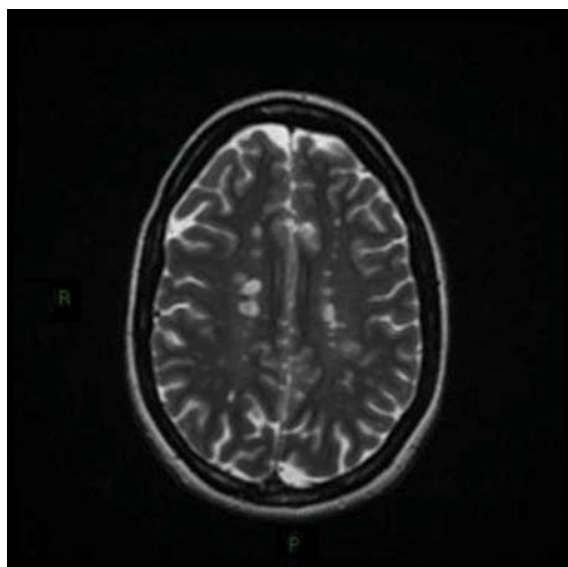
Axial T2-weighted image showing multiple ovoid periventricular white matter lesions, from subject 3.
